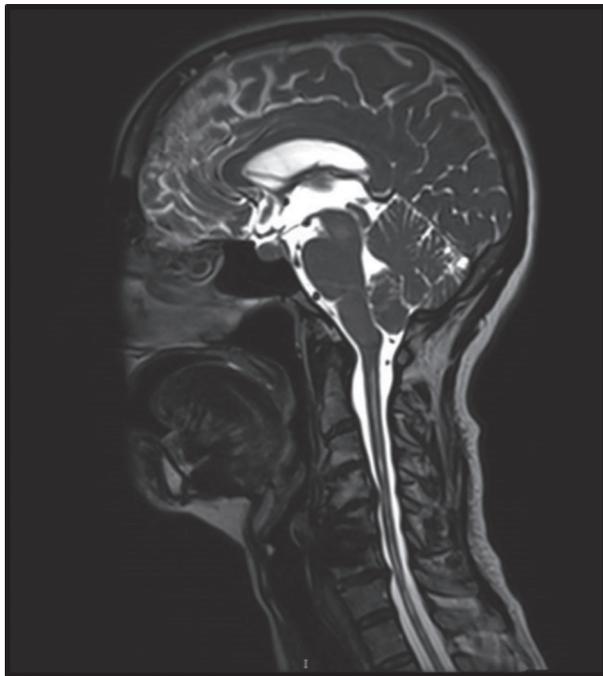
Cervical spine T2 MRI with syringomyelia C2-T1
